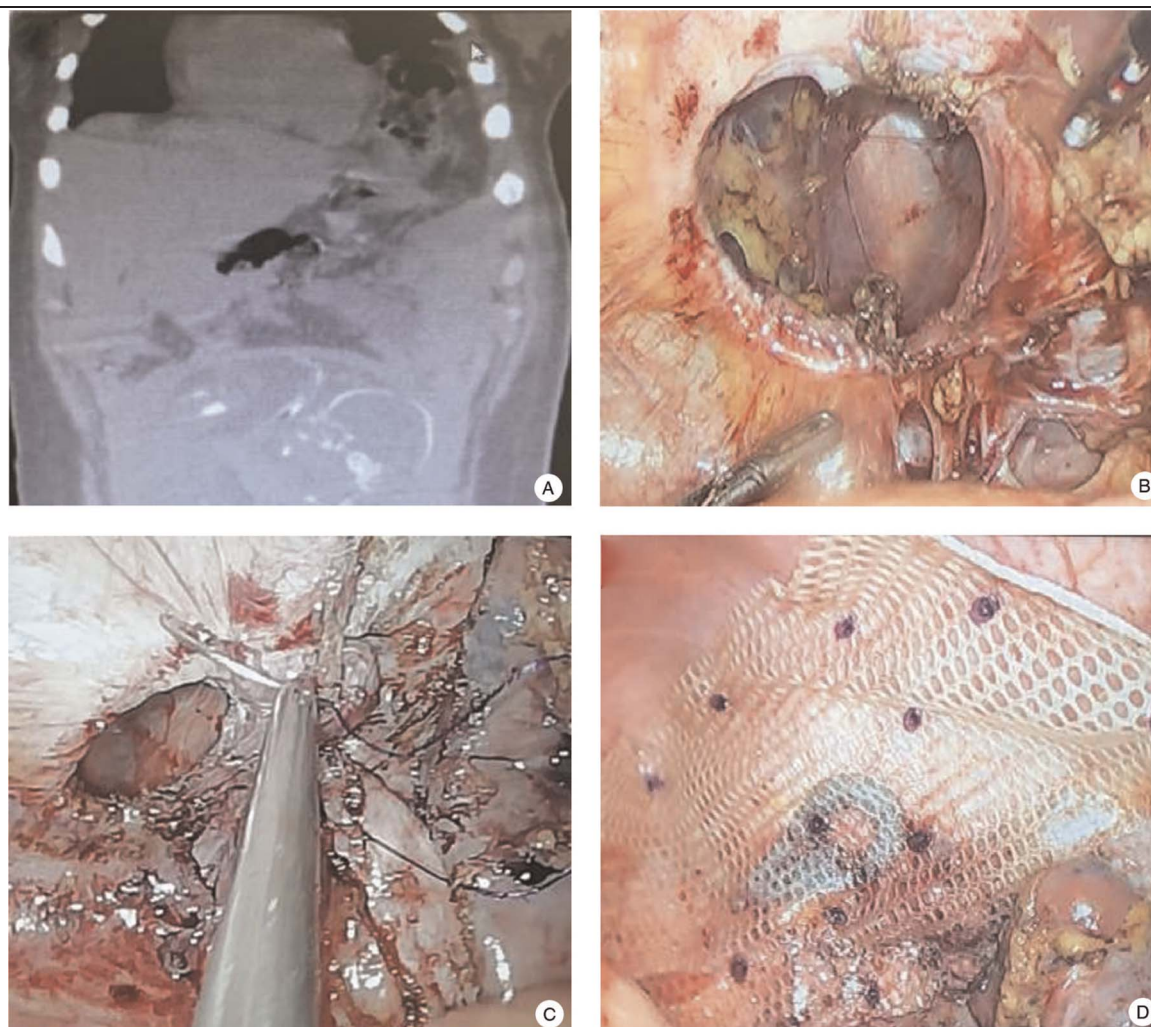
Images of the diaphragmatic hernia. A. Contrasting thorax CT scan showing left diaphragmatic hernia with gastric content at intrathoracic level. B. Hernial defect at diaphragmatic level (5–6 cm). C. Defect correction with suture. D. Mesh placed over the repaired area and fixed with mechanical suture.
